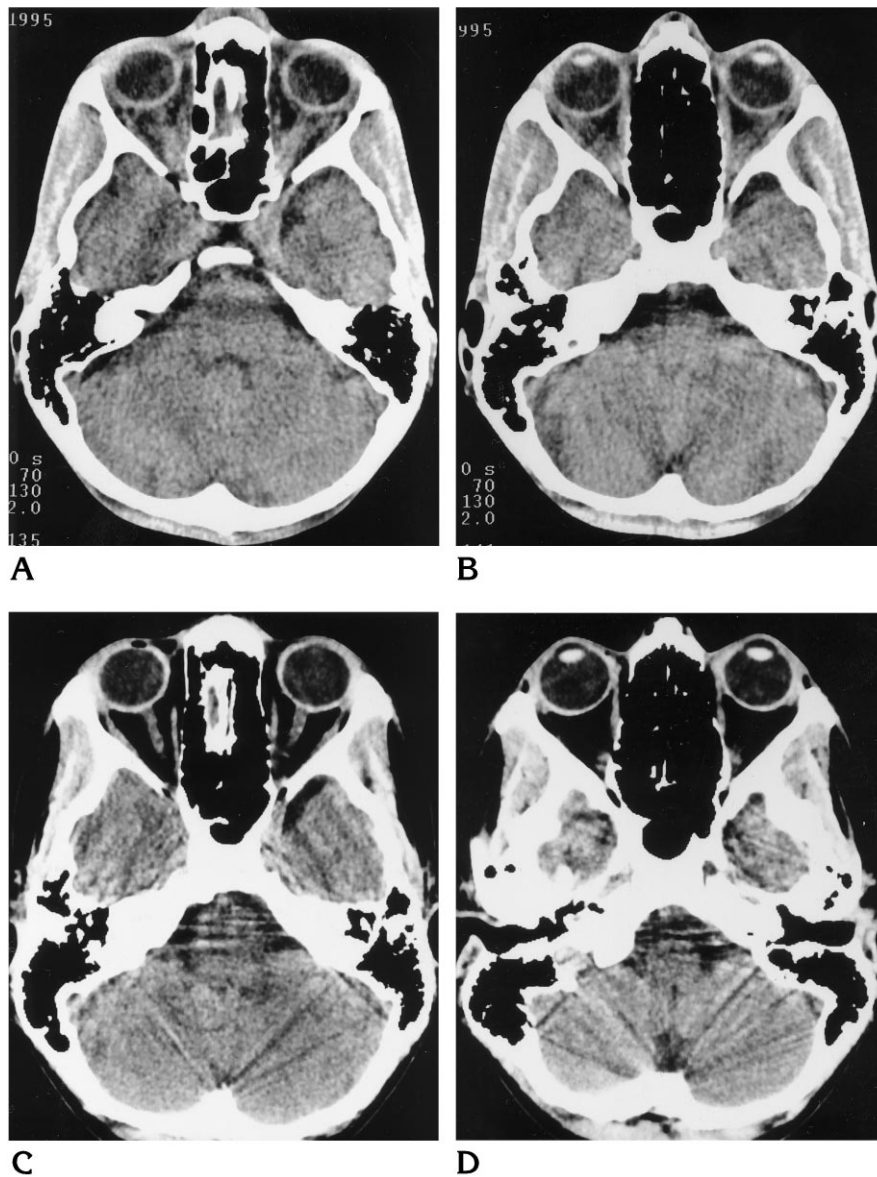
CT in a 28-year-old woman with severe anorexia nervosa.
